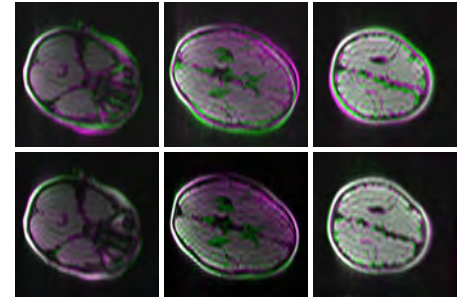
T2-FLAIR blade #14 (child #1). Difference images of slices 7/8 (left), 14/15 (center), 24/25 (right) - before (top) and after (bottom) intra-blade volume correction.
